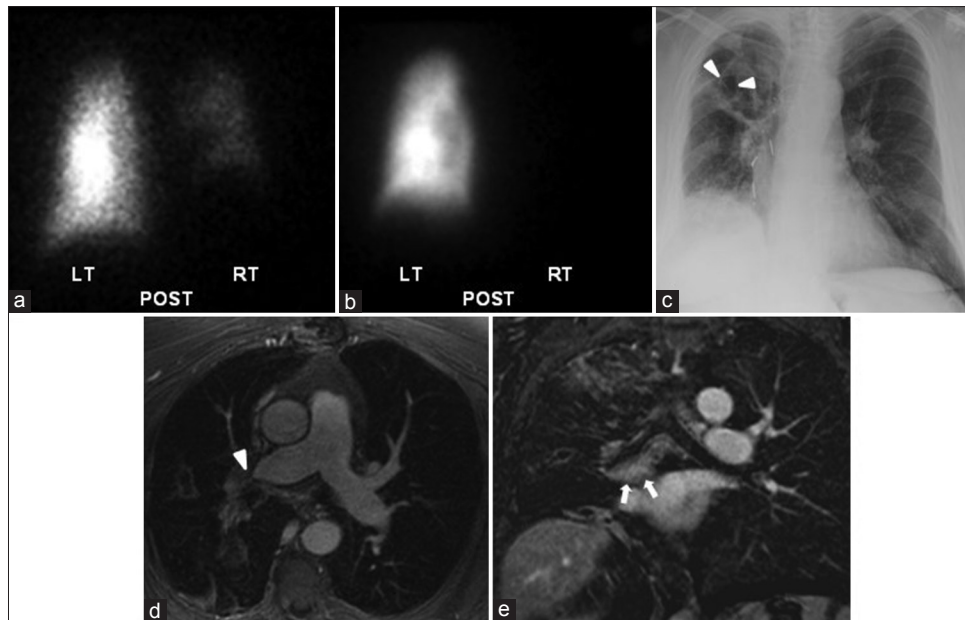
Fibrosing mediastinitis. (a and b), Ventilation-perfusion scans: Severely decreased ventilation (a) and no perfusion (b) to right lung. (c) Chest radiograph: right lung decreased volume, surgical clips, nodules, band-like opacities, and cavities (arrowheads). (d and e), T1-weighted postcontrast (gadofosveset) magnetic resonance images. Axial fat-saturated image (d): Narrowing and distal occlusion of the right pulmonary artery (arrowhead). Coronal motion-corrected subtraction image (e): Abnormally enhancing soft tissue encasing carina and right mainstem bronchus (arrows). LT: Left; POST: Posterior; RT: Right
